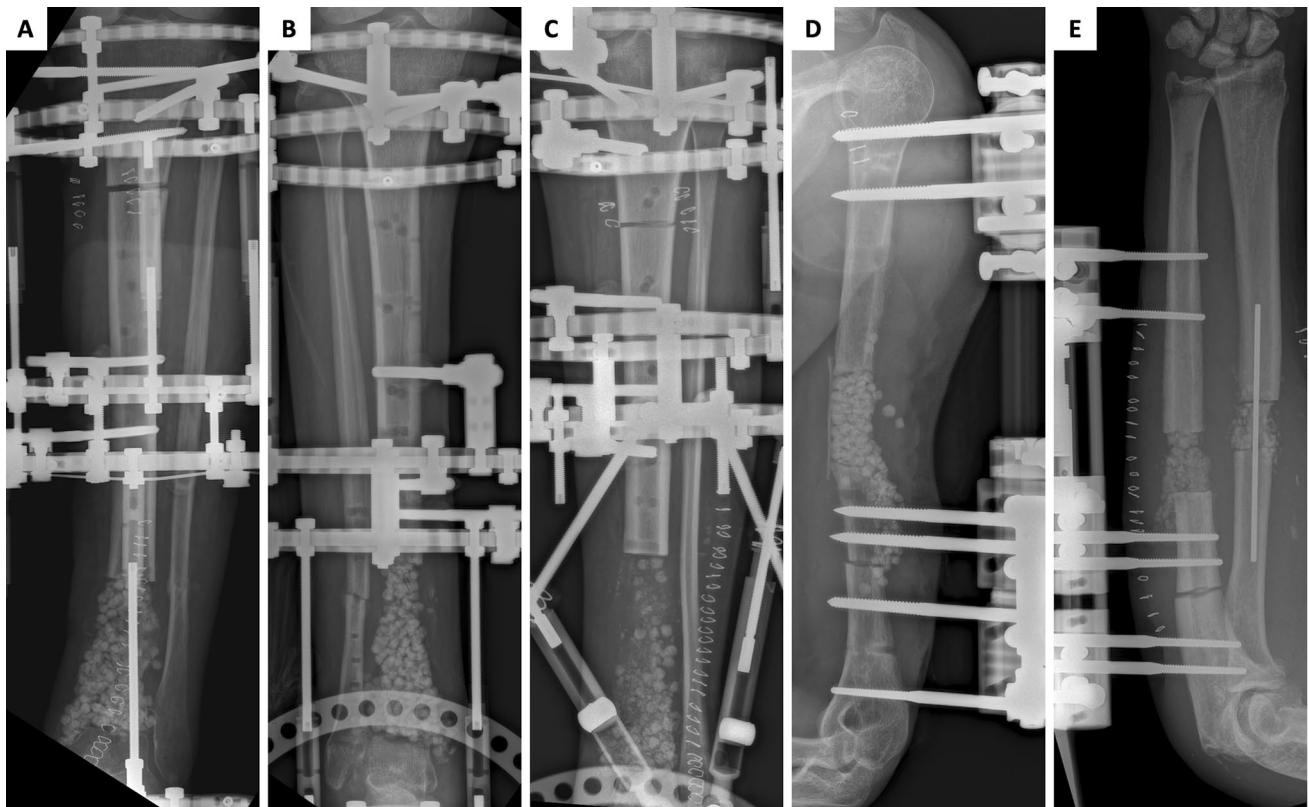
Postoperative radiographs of the bone segments after debridement and bone transport surgery. A: patient 1. B: patient 2. C: patient 3. D: patient 4. E: patient 5
